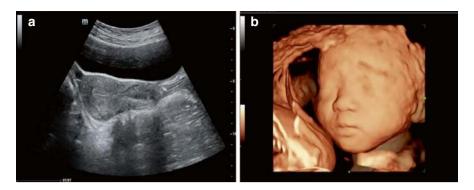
(a) An abdominal 2D ultrasound image showing a longitudinal view of the uterus was obtained via transabdominal scanning. (b) Transabdominal volume ultrasound scan image displaying a fetal facial volume in surface mode
